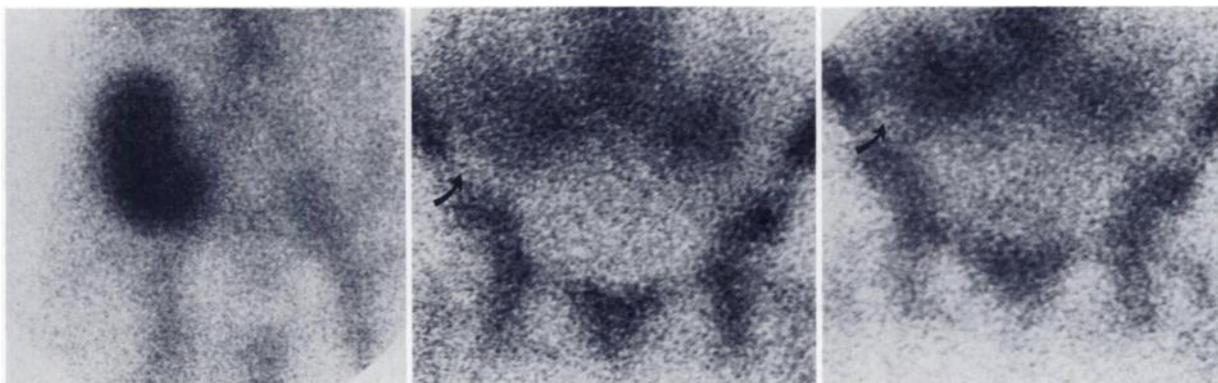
Tc-99m DTPA 1-min scintigram (left). Prompt clearance of radiopharmaceutical indicates good renal function. Two-hour (center) and 24-(right) ILL scintigrams show renal allograft activity (arrows) approaching that seen in adjacent lumbar spine. Contralateral iliac fossa shown only minimal ILL activity.
